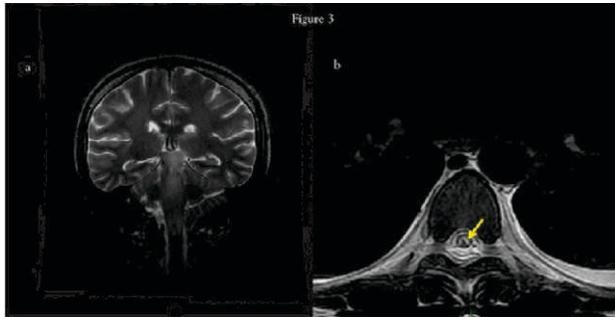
MRI Cervical Spine
